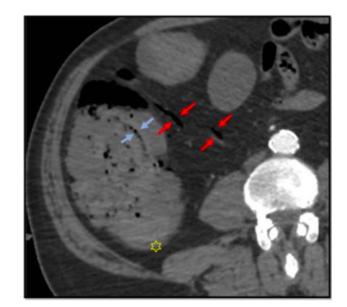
Axial slice of contrast-enhanced abdominopelvic computed tomography demonstrates ascending colon wall thickening (yellow star), portomesenteric venous gas (red arrows), and pneumatosis intestinalis (blue arrows).
